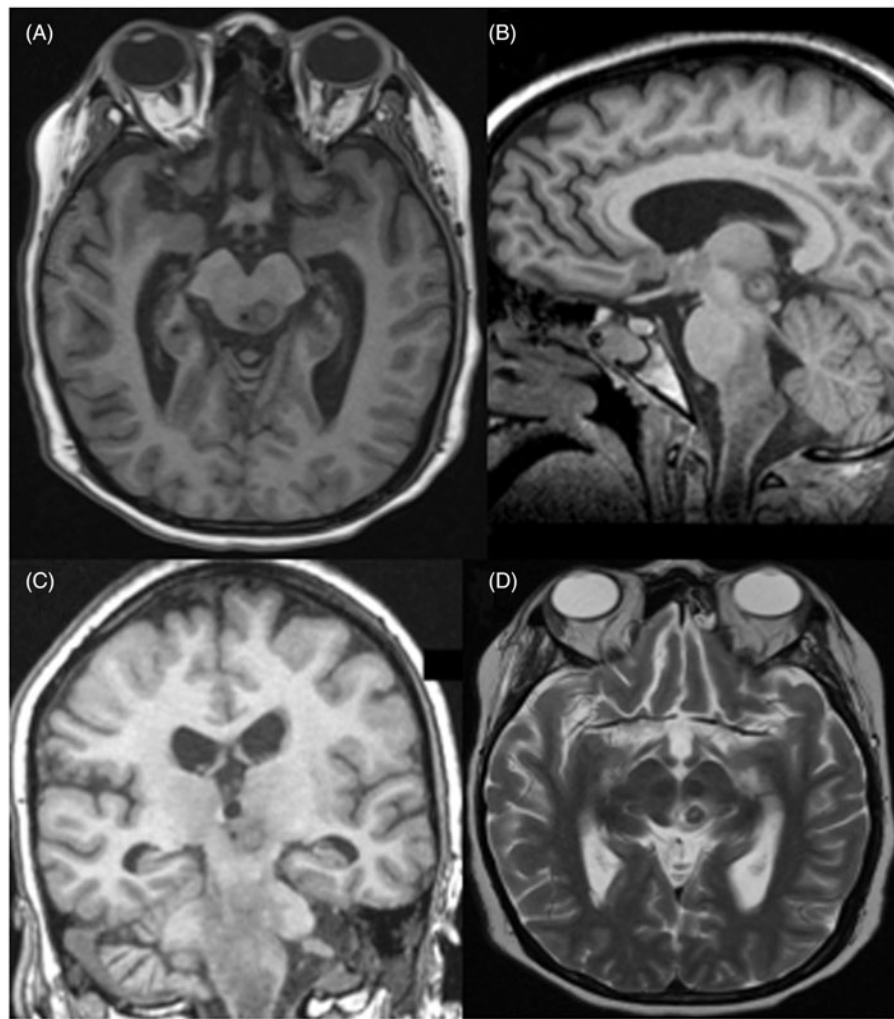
Post-mesencephalotomy brain MRI demonstrating the ablation lesion in the midbrain with T1 axial (A), sagittal (B) and coronal (C) images, and T2 axial (D) image at the level of the inferior colliculus.
